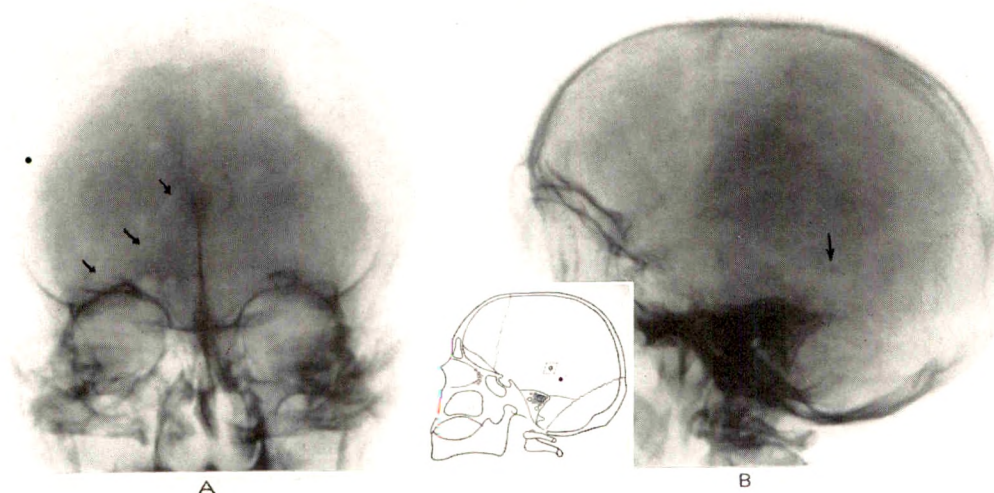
A. Posteroanterior roentgenogram of a skull showing an enlarged meningeal channel in the left frontal region. B. Shows posterior and downward displacement of the pineal body. This with the enlarged meningeal channel permitted the roentgen diagnosis of a left frontal lobe tumor. This was confirmed at operation.
